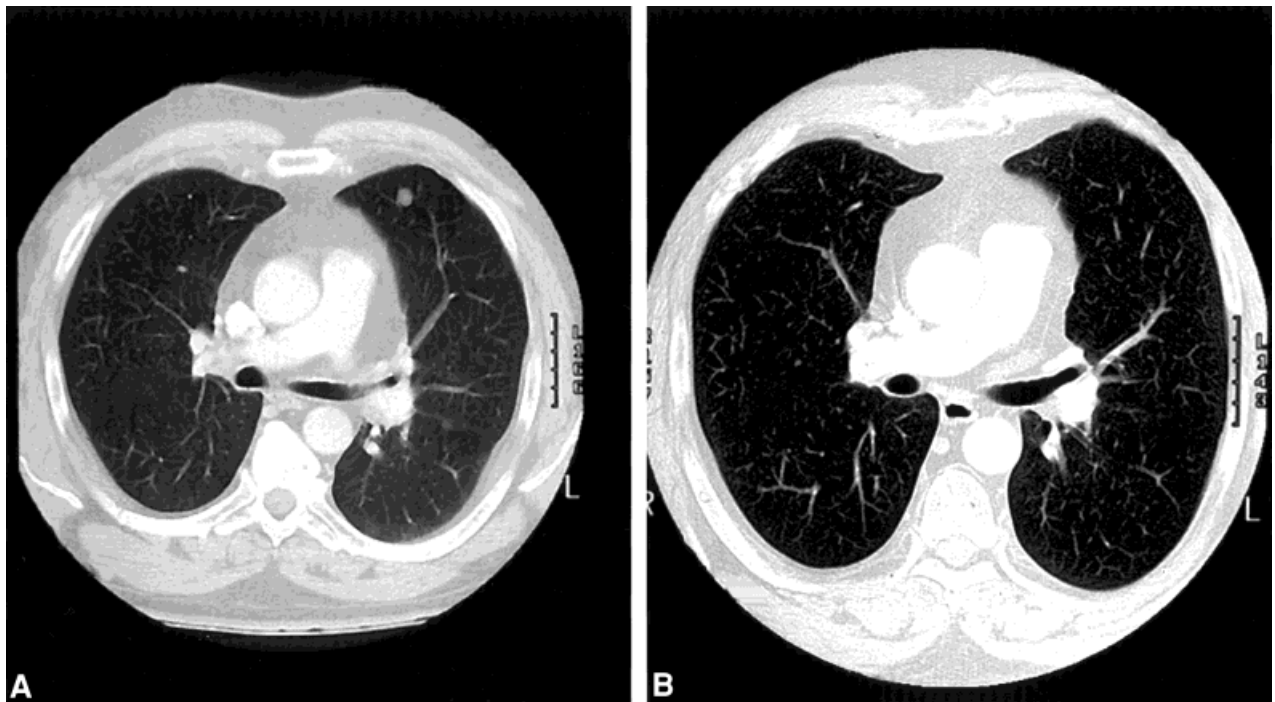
A complete response for Patient 1 is represented. (A) Before: Computed tomography (CT) shows pulmonary nodules prior to the start of chemotherapy. (B) After: This CT followed six cycles of paclitaxel and tamoxifen.
